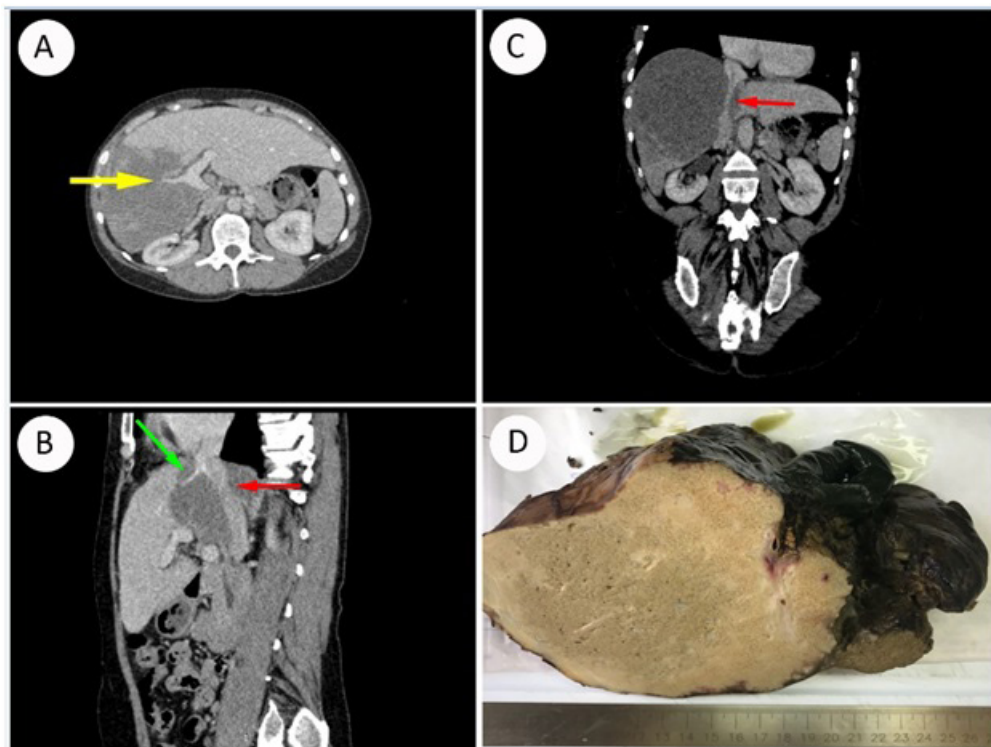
Enhanced multiphase axial (a), sagittal (b) and coronal (c) CT scans obtained in venous phase shows right branch of portal vein invasion (yellow arrow) and circular invasion of vena cava inferior (red arrows) and middle hepatic vein (green arrow). (d) Macroscopic picture of alveococcosis of the right lobe of the liver.
